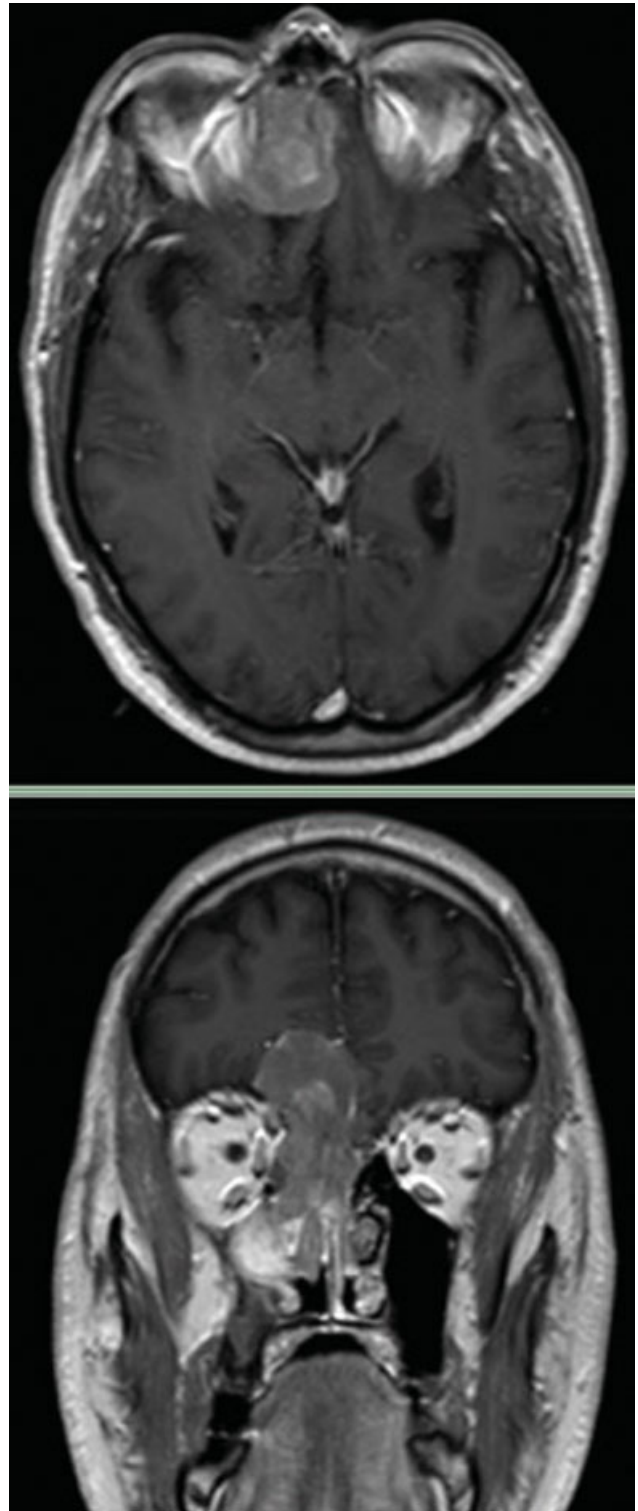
Magnetic resonance imaging showing skull base erosion and intracranial extension.
